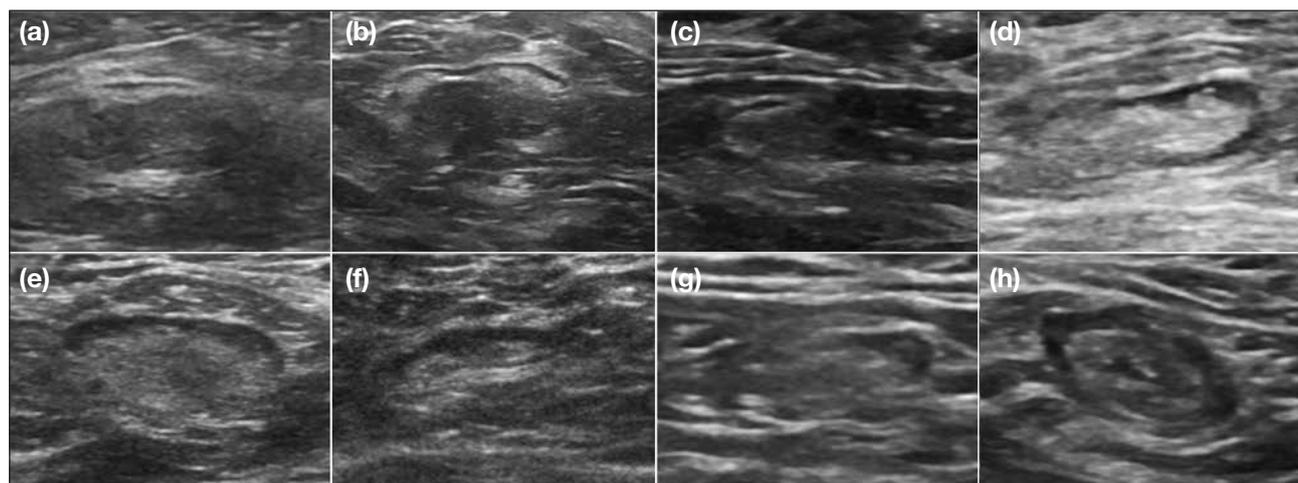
Ultrasound images of selected lymph nodes in the low suspicion group (Group 1), which were those with smooth regular thin cortex (<3 mm) and a central echogenic hilum without compression or displacement. Hypoechoic areas in the central hilum were demonstrated in Figure 4a to c, which may be due to composition consisting of mostly homogeneous fat cells and relatively scanty vessels.
